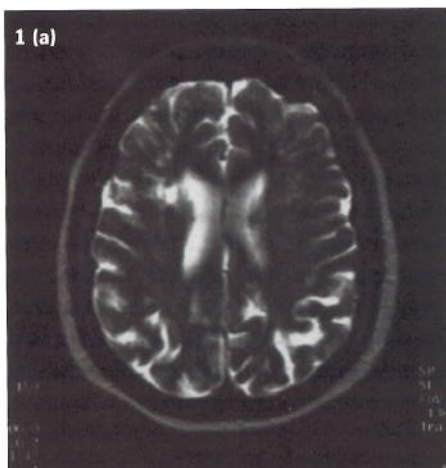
Conventional T2-weighted MRI (a) and CT (b) of acute stroke patient are negative.
